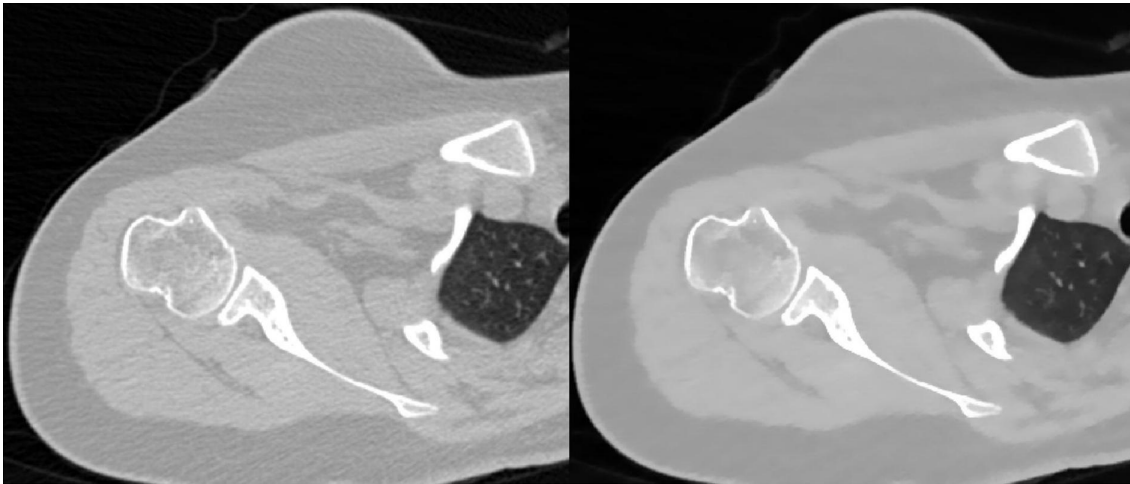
Left, the original image form a CT scan of a shoulder joint, Right, bilateral noise removal method filter applied.
